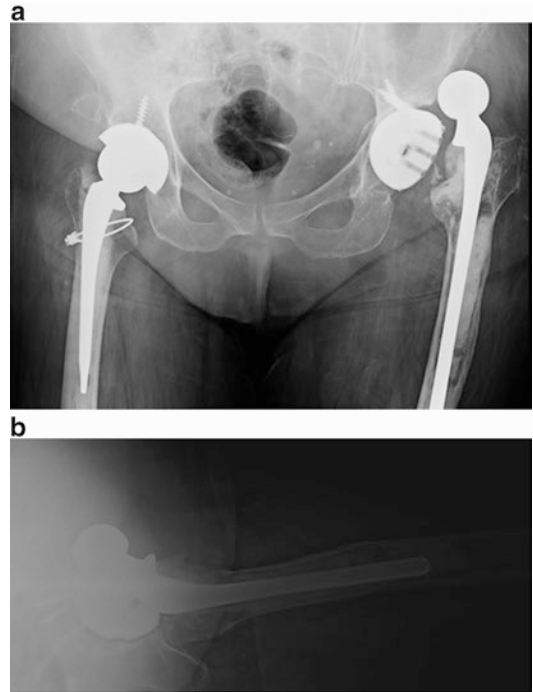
Anteroposterior pelvis (a) and cross-table lateral hip (b) radiographs revealing an anteriorly dislocated total hip arthroplasty. The acetabular component is grossly loose and there is suspected loosening of a long-stem, cemented femoral prosthesis
